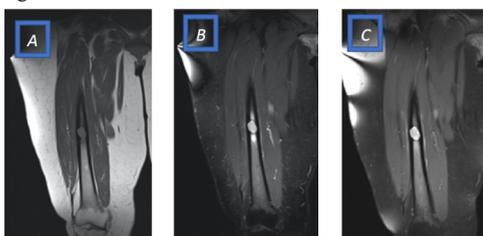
MRI coronal T1WI(A), T2WI(B) and T1 post-contrast(C)
